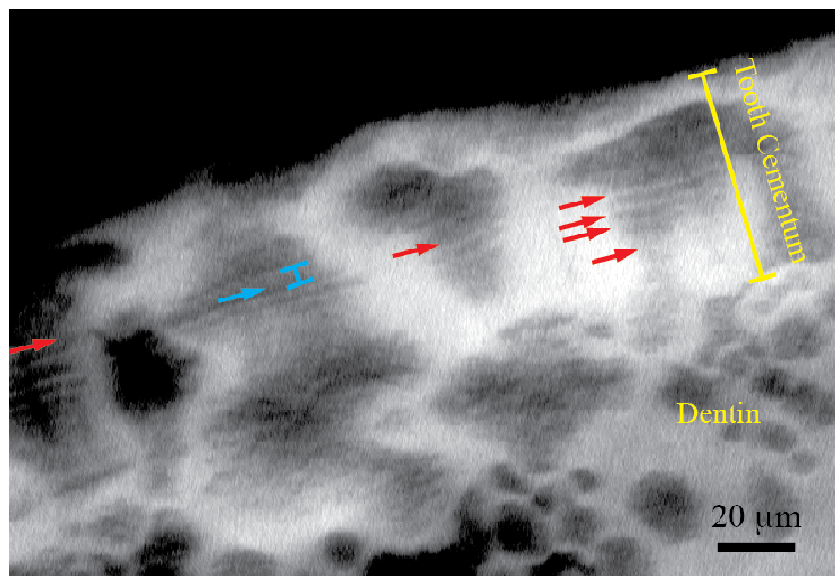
SR $\mu$ CT scan with a pixel size of 0.33  $\mu\text{m}$  of a premolar of a 36-year-old woman. Cementum with the ILs (red arrows) is presented, and one IL (blue arrow and balk) appears broader compared to the other ILs.
